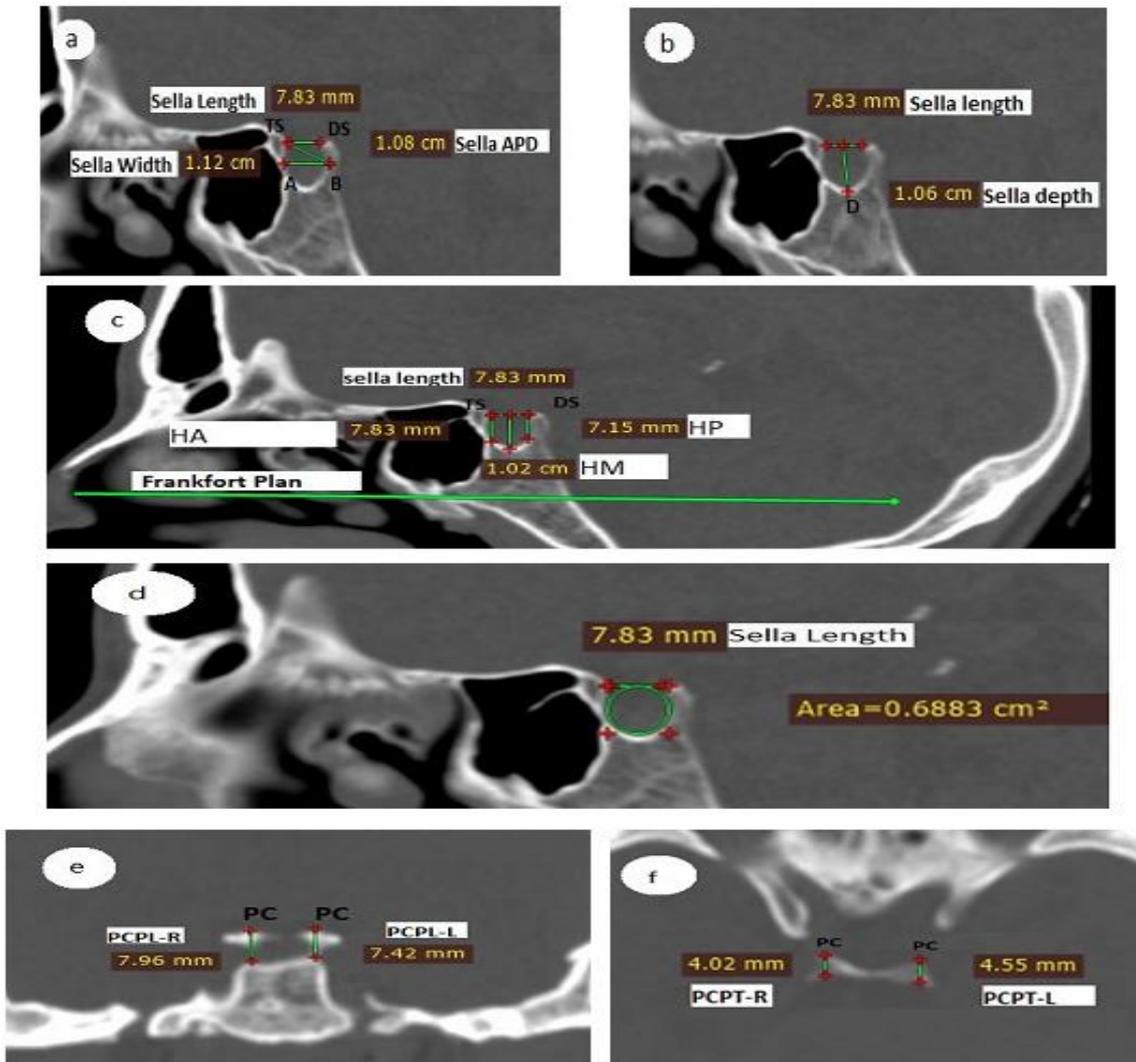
Multiplanar Reconstruction (MPR) CT images of a male skull showing Sella Turcica measurements and bony land marks: (a), (b), (c) and (d) are in midsagittal plan, (e) is in coronal and (f) is in axial plan. (a) showing Sella length: the distance between (TS) tuberculum sella and (DS) dorsum sella; Sella width: the distance between (A) the most anterior part in the anterior wall and (B) the most posterior part in the posterior wall; APD: anteroposterior diameter : the distance between TS and B. (b) showing Sella depth : distance between (D) the depest point in Sella floor and the line presenting Sella length. (c) showing HA: height anterior: the distnace between TS and the Sella floor; HM: height median the distance between the mid point of line representing the length and the Sella floor, HP: Height posterior the distance between DS and the Sella floor. HA, HM and HP all are perpendicular on the green arrow which represents the Frankfort horizontal plan. (d) Showing the area of Sella Turcica bounded by the line representing Sella length. (e) Coronal plan showing PCPL-R: posterior clinoid process length right side and PCPL-L: posterior clinoid process length left side measured as : the distance between PC the apex of posterior clinoid process and the floor of Sella on both sides. (f) Axial plan showing PCPT-R :Posterior clinoid process transverse thickness right side and PCPT-L: Posterior clinoid process transverse thickness left side measured as: the distance between PC and the back of posterior clinoid process on both sides.
